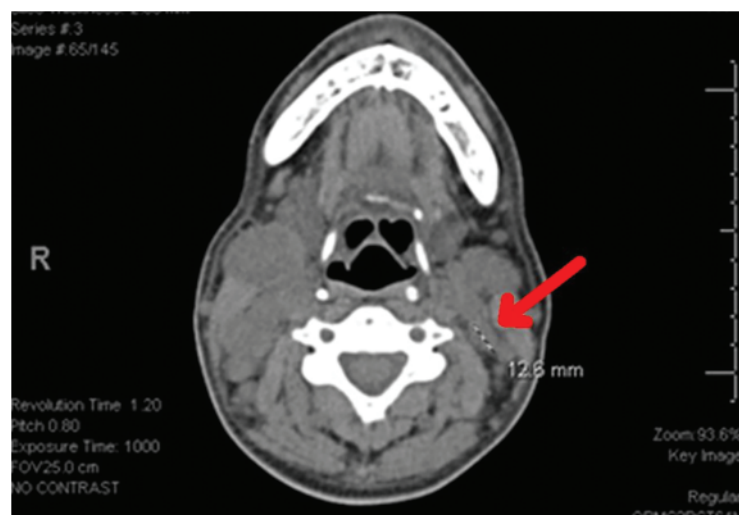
CT soft tissue of the neck shows cervical lymphadenopathy (red arrow).
